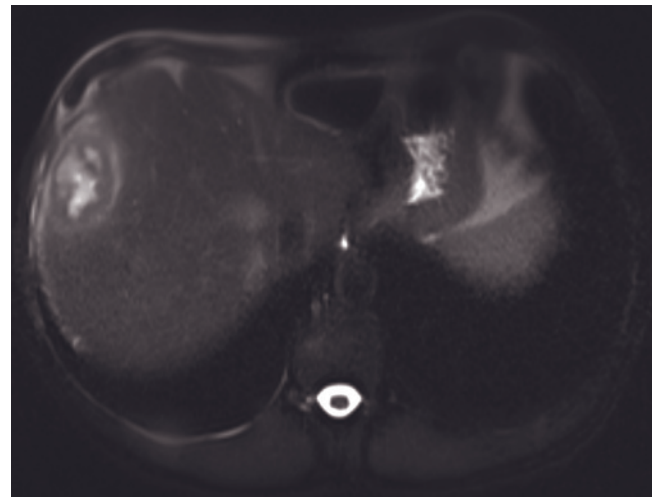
(Continued) Coronal T2-weighted SS-ETSE (*b*), SGE (*i*), and immediate (*j*) and 90-s (*k*) postgadolinium SGE images in a third patient. There is a lesion in the dome of the liver that exhibits mildly low signal intensity on T1-weighted image (*i*) and mild enhancement on all phases after contrast (*j*, *k*). Also, note the liver retraction in the dome of the liver adjacent to the tumor, best seen on the coronal T2-weighted image (arrow, *b*). Inflammatory myofibroblastic tumor may range in appearance from a vascular active multifocal process to irregularly margined, poorly enhanced fibrosed lesions. Unlike in other conditions (e.g., metastases and abscesses) this range of appearance can occur with no history of treatment of the active disease.
